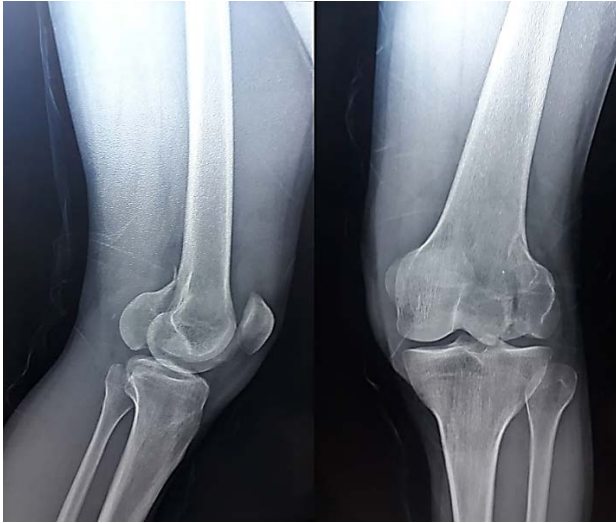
X-rays; Hoffa fracture of lateral condyle
